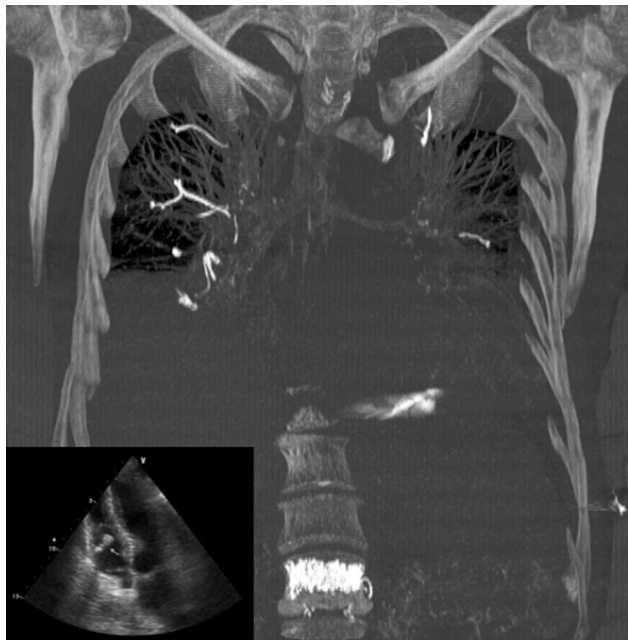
Coronal maximum intensity projection of the thoracic computed tomography scan, revealing multiple cement emboli in the right ventricle, in segmental and subsegmental arteries of the right upper and lower lobes, and in segmental arteries of the left lower lobe. *Inset*, apical four-chamber view in a transthoracic echocardiogram. Note the hyperechogenic foreign body in the right ventricle (arrow).
